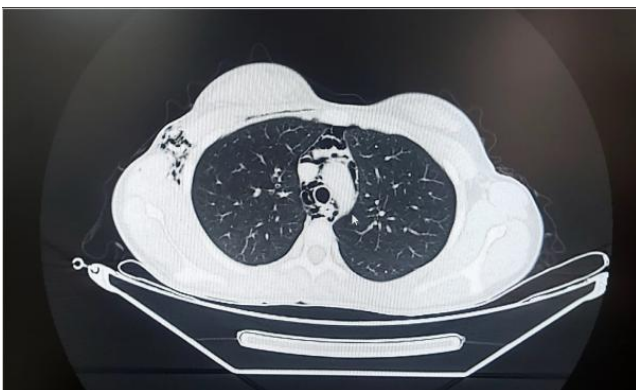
Thoracic computed tomography demonstrated extensive subcutaneous emphysema and pneumomediastinum, predominantly localized within the anterior mediastinum.
